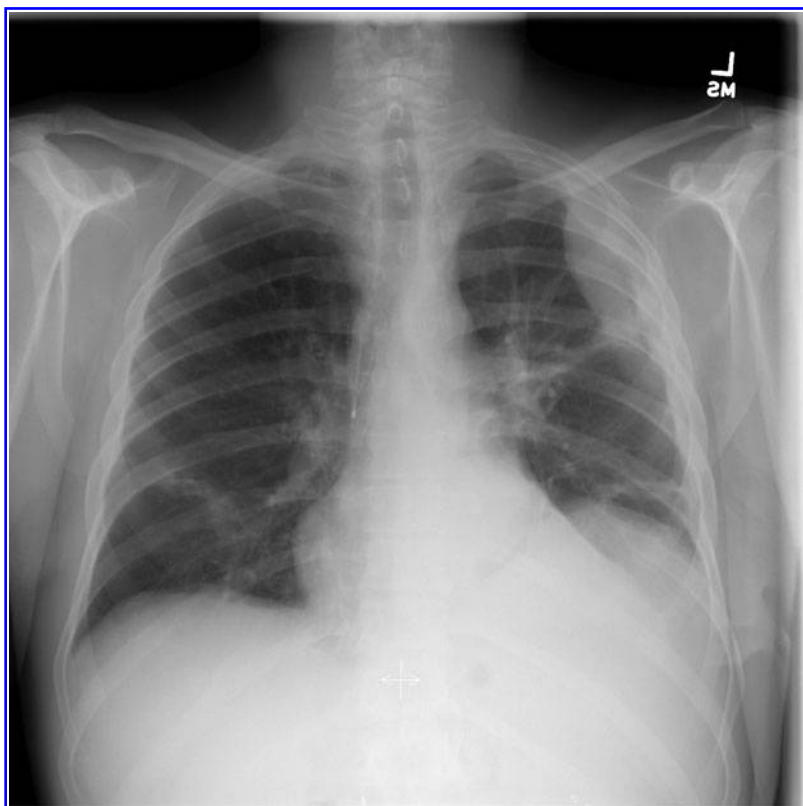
Chest radiograph after extracorporeal membrane oxygenation decannulation, weaning from mechanical ventilation, and tracheostomy decannulation.
